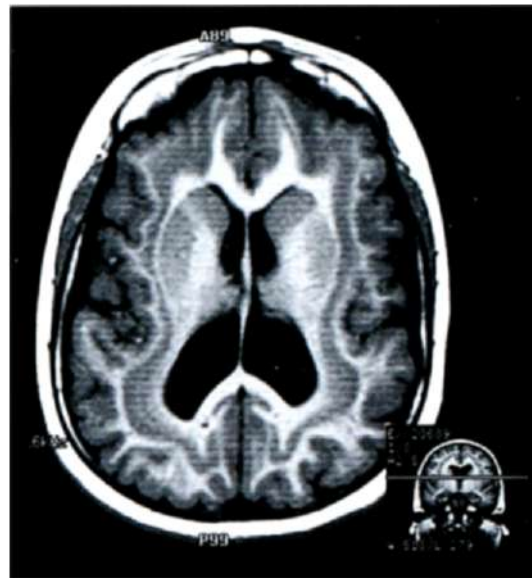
Axial T1-weighted MR image of a diffuse band heterotopia. Note the sharply demarcated band of neurons in between the cortex and the ventricles giving the appearance of a "double cortex."
